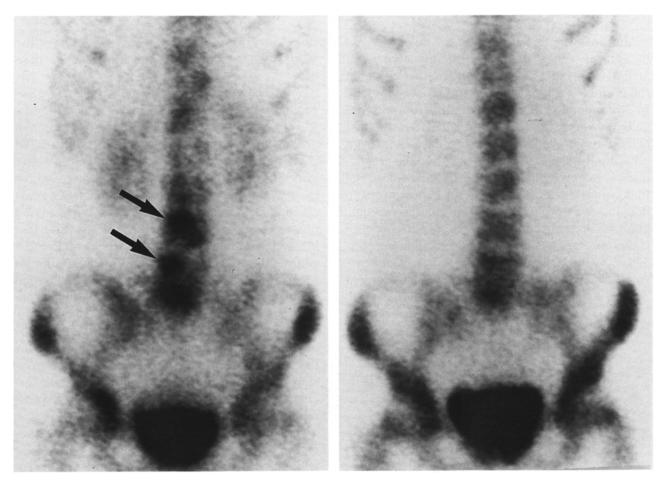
Bone scintigram 5 days after admission revealed multiple bone metastases (left), and 4 months later, bone scintigram showed decreased uptake in the lumbar spine (arrow) (right).
